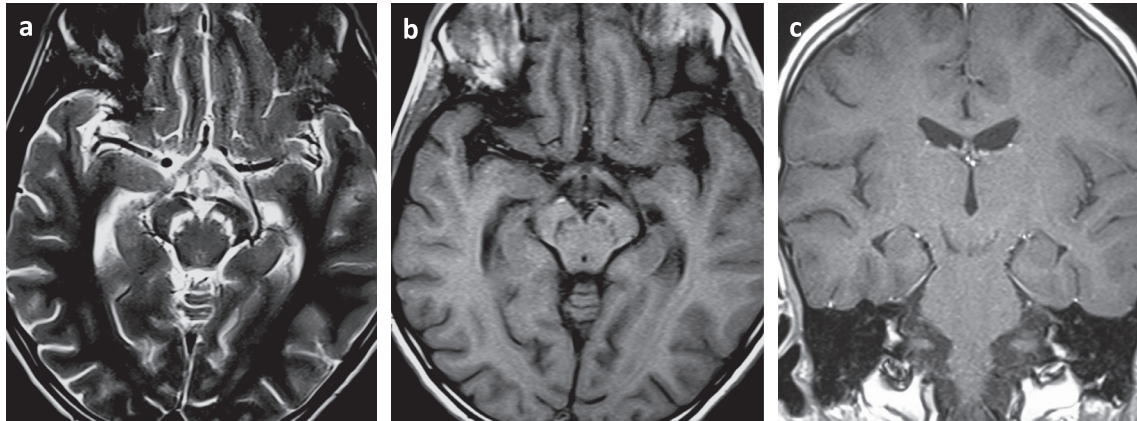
Axial brain MRI (a and b) showing bilateral hypersignal of the substantia nigra on T2-weighted image (a) with decreased signal on T1-weighted image (b). No contrast enhancement was noticed on coronal T1 weighted image with gadolinium (c).
